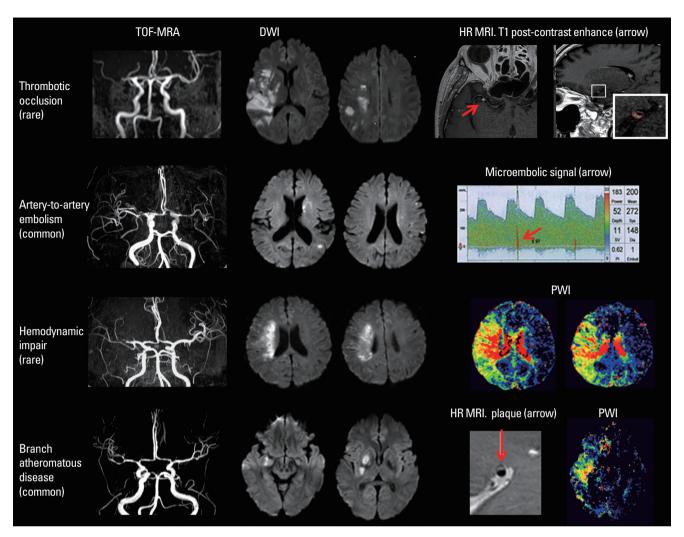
Mechanisms of stroke in patients with ICAD. (A) Thrombotic occlusion is a rare phenotype of ICAD. Magnetic resonance angiography (MRA) shows in situ thrombotic occlusion at the site of stenotic plaque. DWI shows territorial infarcts by severe hemodynamic compromise and embolic infarcts on the cortex. High-resolution MRI can show vulnerable plaque on intracranial vessels. (B) Artery-to-artery embolism is one of common phenotypes of ICAD. Artery-to-artery embolism is usually associated with a severe degree of intracranial stenosis, and transcranial Doppler ultrasonography can detect symptomatic or asymptomatic embolism during microembolic signal monitoring. DWI shows small, scattered, cortical embolic infarcts. (C) Hemodynamic impairment is another phenotype of ICAD. This phenotype is usually associated with a severe stenosis and a marked hemodynamic compromise, as seen on a perfusion-weighted image (PWI). DWI typically shows borderzone-type infarcts, and infarct growth is common with clinical deterioration. (D) Branch occlusive disease is a common phenotype of ICAD. This phenotype is often misclassified as small arterial disease due to a mild degree of stenosis on MRA, small deep infarcts on DWI, and relatively small perfusion defects. High-resolution MRI can reveal plaque without stenosis near the orifices of penetrating arteries.
